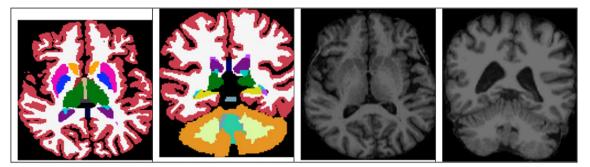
Brain volumetric MRI study in PD patients with segmented axial, coronal sequences on the RT side, non-segmented axial, coronal sequence on the LT side showing reduction in mean cortical thickness, total cerebral WM volume, total cortical volume and total gray matter volume (original images from patients enrolled in the study)
